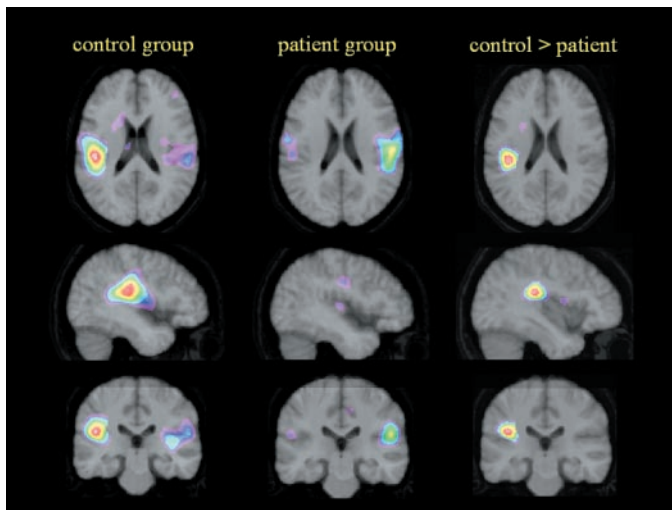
Activated clusters indicated by the right-sided caloric vestibular stimulation (*left* and *middle*) and the activation pattern revealed by the response difference approach (*right*), superimposed on the spatially standardized, averaged T1-weighted MR data of the populations.
